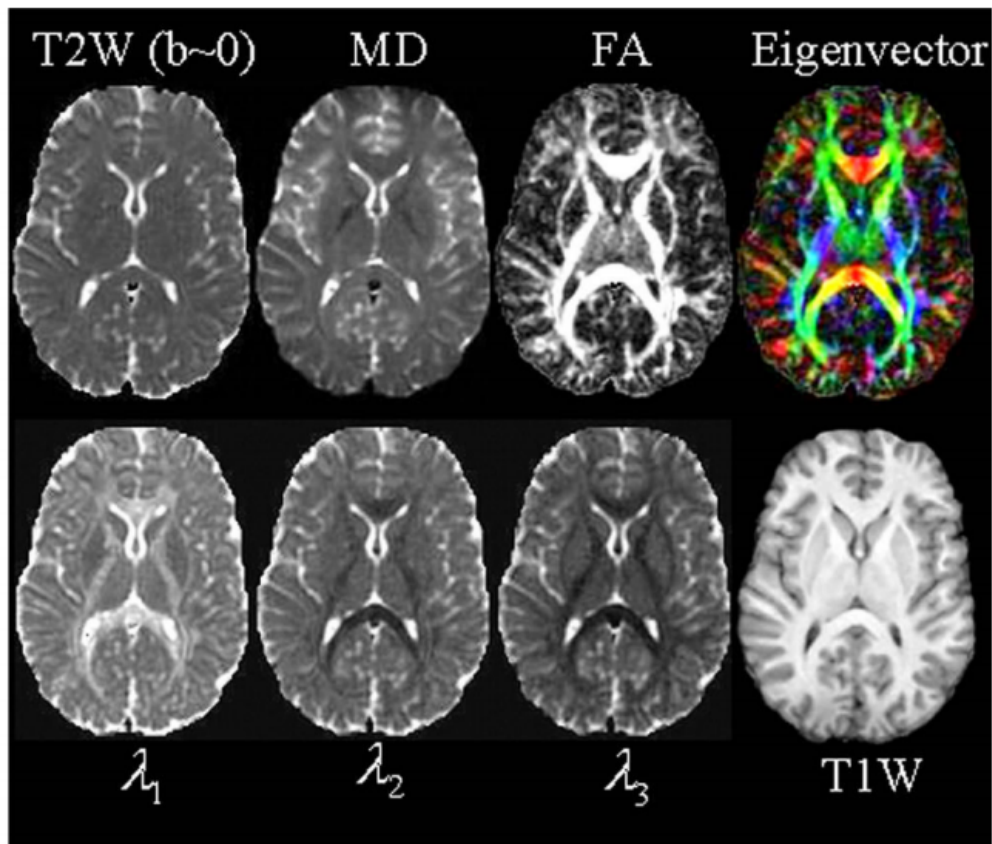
DTI vs. MRI. A summary of DTI compared to standard MRI imaging. Taken from [35], where it appears as Figure 4. A spatial map is shown of (from top left) a T2-weighted image, the mean diffusivity, the FA, the principal direction (with direction indicated by colour), the three principal values, in descending order, and a T1-weighted MRI image.
